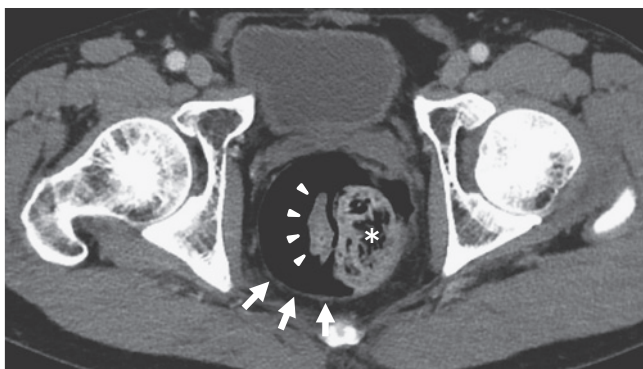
Contrast-enhanced abdominopelvic computed tomography scan at the hip joint level, showing protrusion of a large pocket (*arrows*) into the rectal lumen (*arrowheads*). The pocket contained a fecal mass (*asterisk*).
